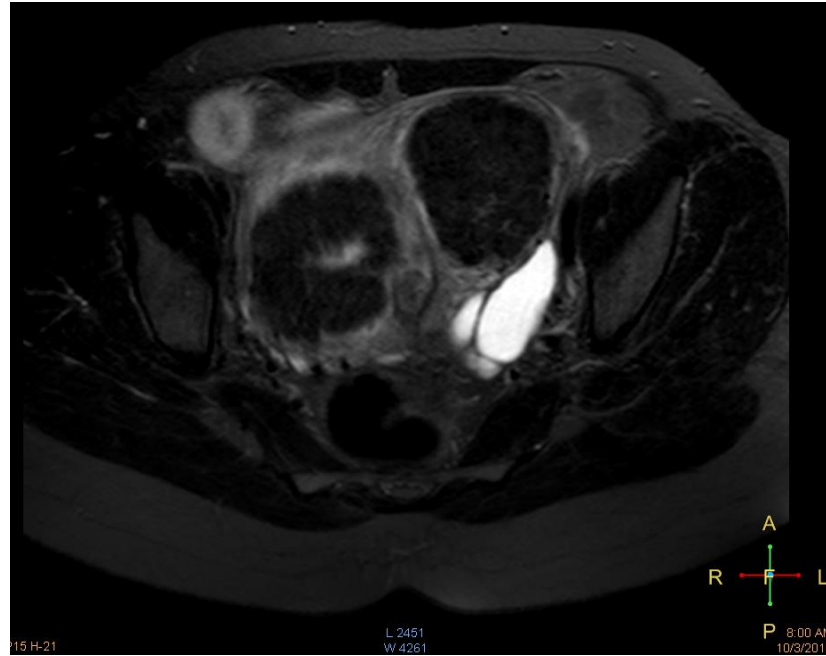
MRI T₂ weighted image of the 3rd patient before HIFU treatment. Two dominant fibroids got MR-HIFU ablated. The fibroid closer to anterior is the 3rd fibroid and the other one is the 4th fibroid got treated in table 4.2.
